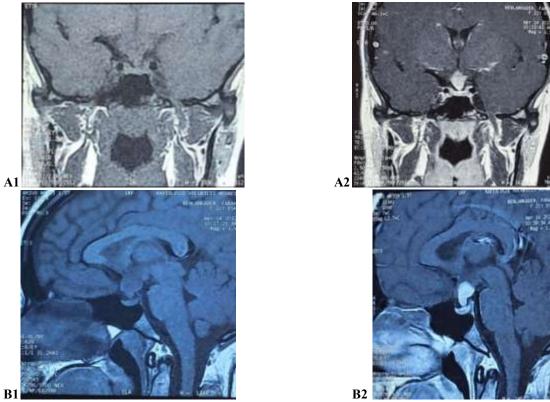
Coronal (A) and sagittal (B) section of T1-weighted (1) and post-gadolinium T1-weighted (2) MRI images of the patient showing a nodular thickening of the pituitary stalk, spontaneously hyperdense, with homogeneous enhancement following contrast administration (performed at Hassan II University Hospital, Fez, Morocco)
